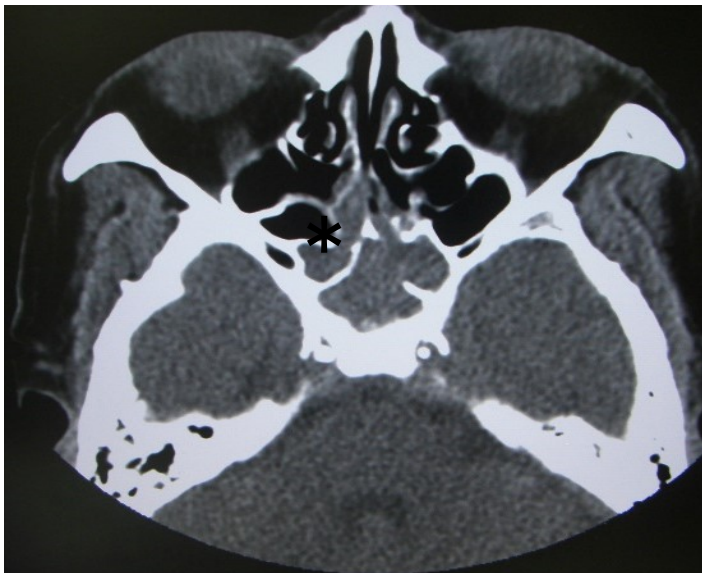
In CT scan, a soft tissue lesion (an asterisk) could be found in the bilateral sphenoid sinus.
